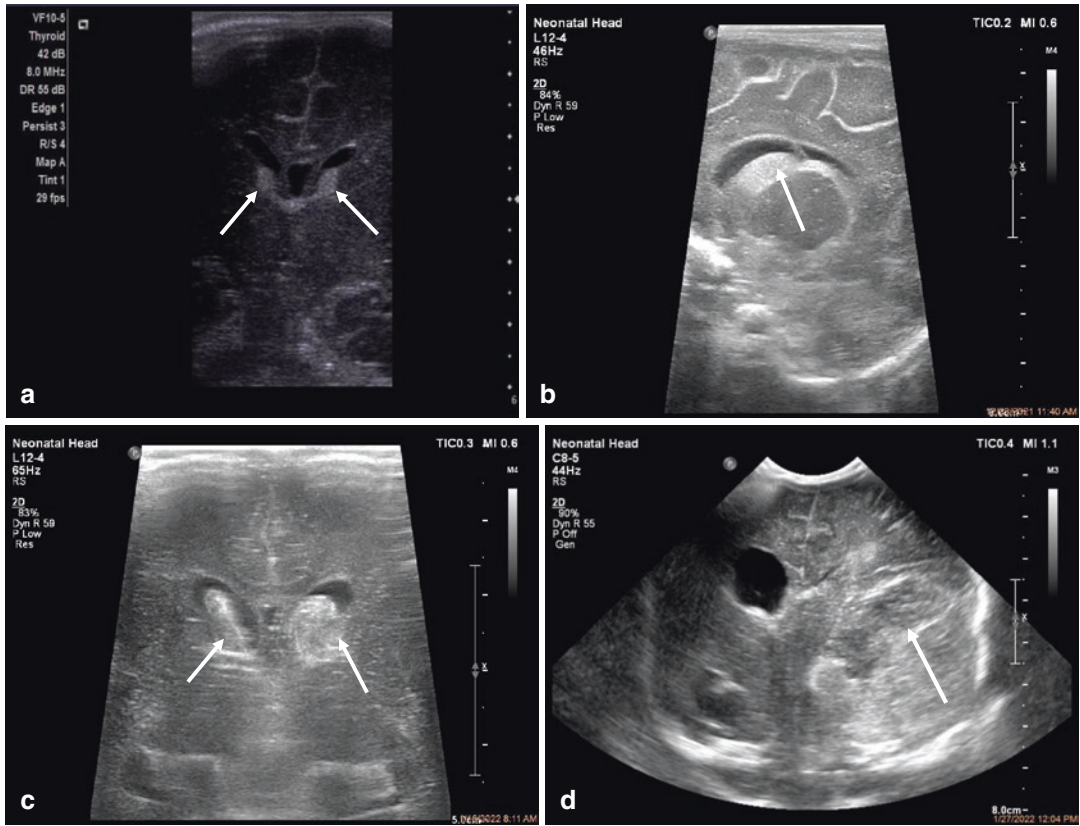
(a) Coronal ultrasound image in a preterm neonate at the level of frontal horns of the lateral ventricles, showing bilateral germinal matrix hemorrhage (arrows; grade 1 IVH), (b) Parasagittal ultrasound scan through right lateral ventricle showing IVH grade 2 (arrow), and (c) Coronal ultrasound image in a preterm neonate with grade
